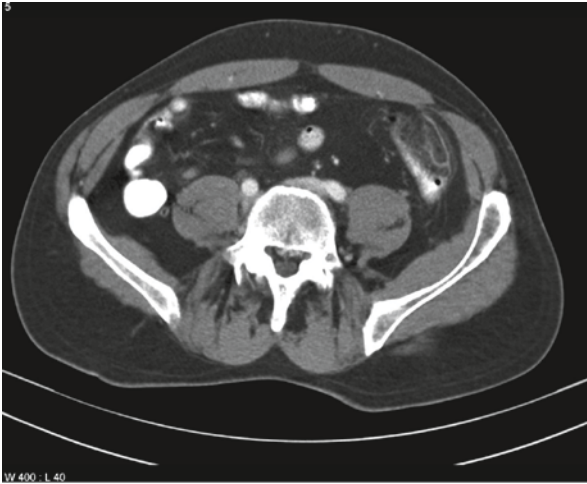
Abdominal CT. Appendagitis: acute inflammation of the appendix epiploica of the sigmoid colon. See the inflammatory process compressing the lumen of the colon
